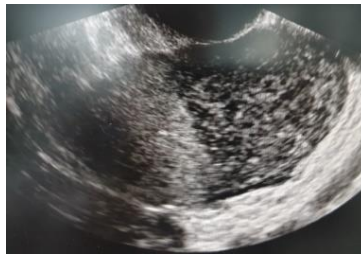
Vaginal ultrasound images showing large ovary (> 4 cm) torted with edema and positive Doppler intra-ovary.
